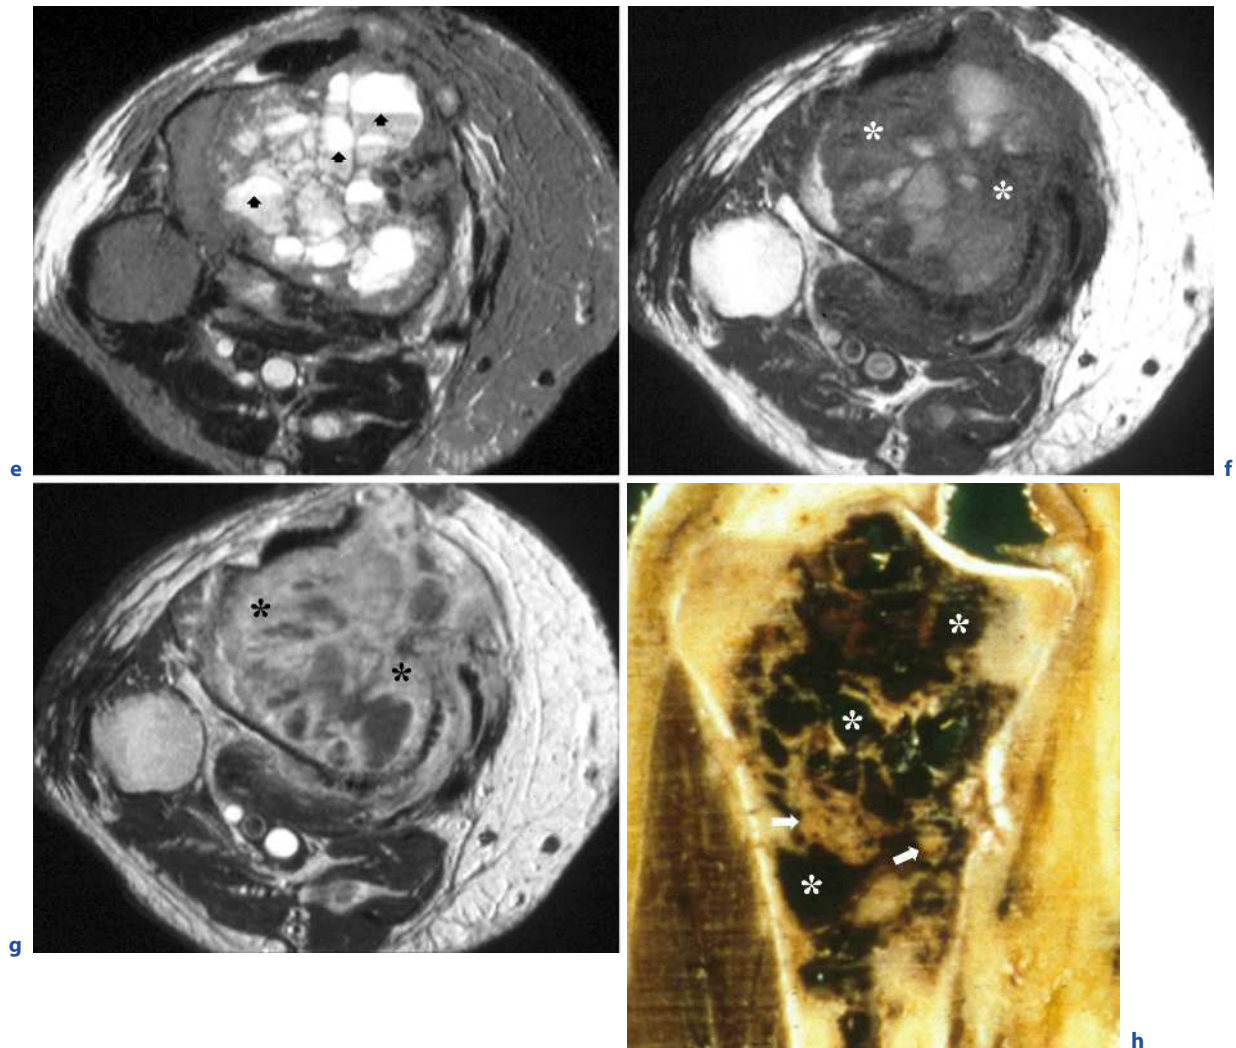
Telangiectatic osteosarcoma of the proximal tibia. a Anteroposterior radiograph shows a large lytic lesion in the proximal tibia with soft tissue extension (*arrows*) and no definitive osteoid formation. b Axial noncontrast CT scan reveals areas of low attenuation (*white asterisks*), as well as others with soft tissue attenuation (*black asterisk*). Corresponding coronal T1-weighted (c) spin-echo and STIR (d) MR images show a predominantly hemorrhagic mass with areas of subacute hemorrhage (*asterisks*) and soft tissue extension (*arrows*). e-h see next page
